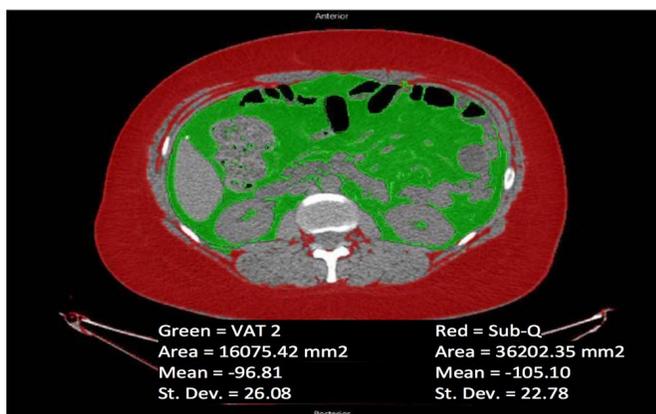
Axial CT slice at the level of the first and second lumbar vertebrae (L1-2).
